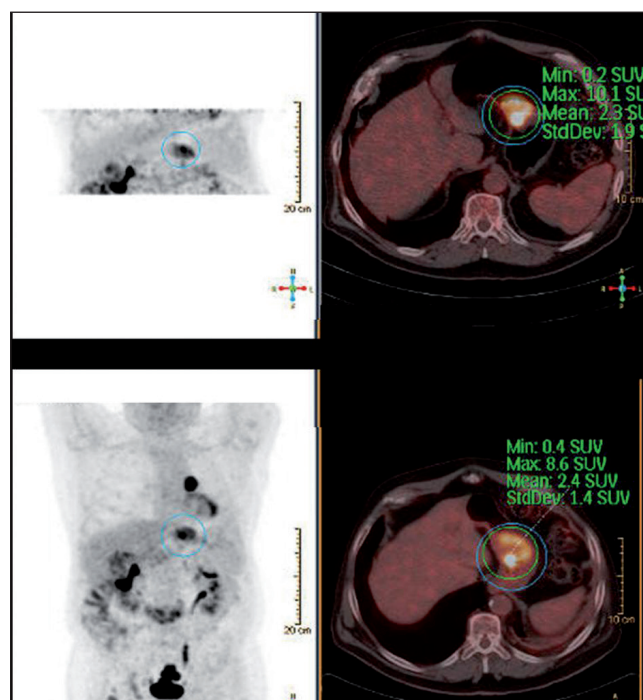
MIP image and axial fusion planes 18F-FDG PET/CT. Late abdominal region acquisition (above) 180 minutes after administration of 6 mCi 18F-FDG and whole body PET/CT performed one hour after injection (below). Comparative of SUV_{max} measurement of gastric uptake in the lesser curvature.
